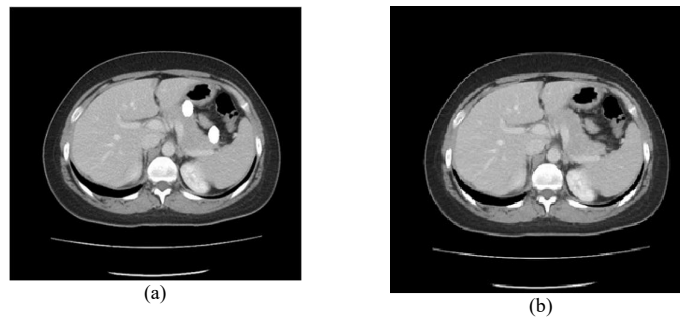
CT image a) Tampered b) Recovered
